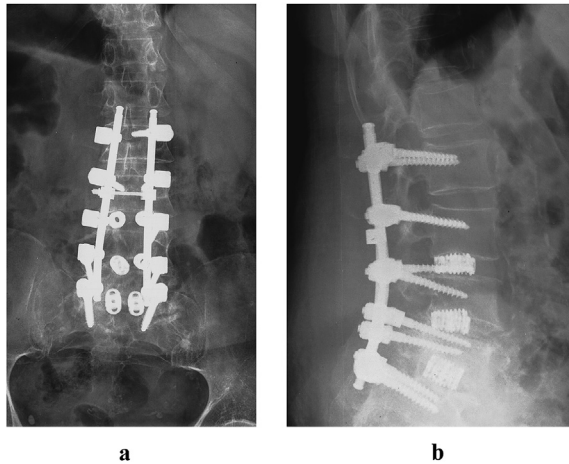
Anteroposterior (a) and lateral (b) radiographs showing L2-S1 decompression and fusion with posterior instrumentation.
